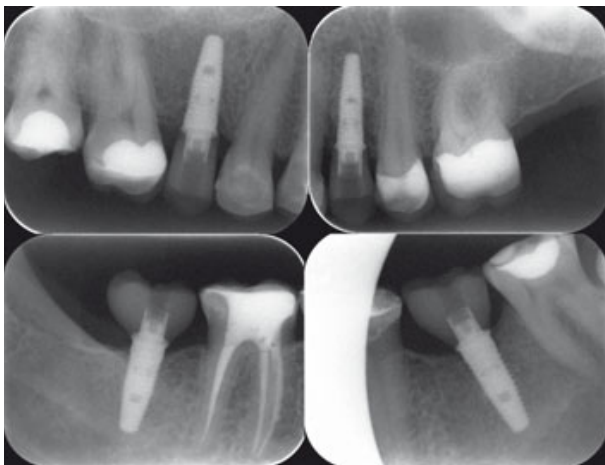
Periapical radiographs of the completed tooth-supported and implant-supported restorations.
